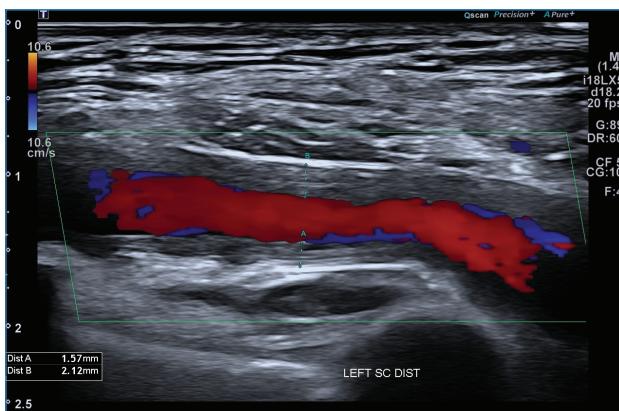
Ultrasound image with colour Doppler flow of the left subclavian artery, depicting a massive increase of the intima-m
